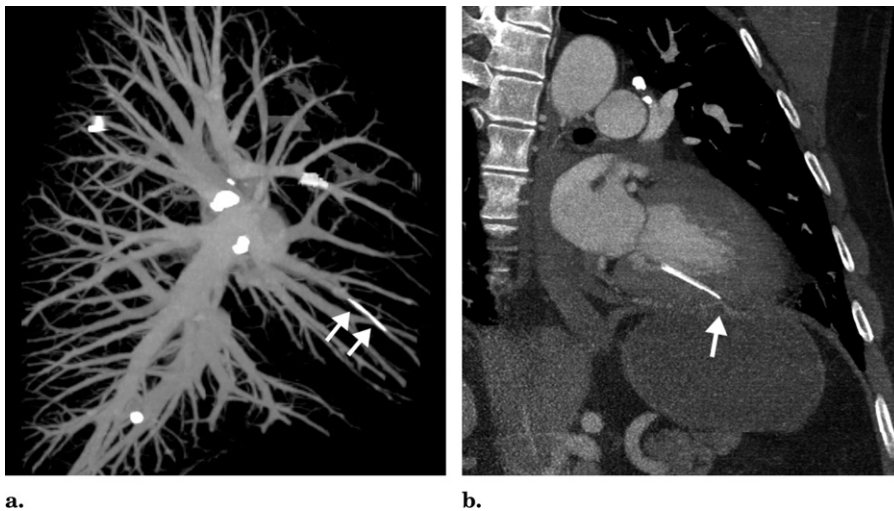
CT scan shows metallic foreign body (arrows) in the right middle pulmonary artery (a) and inferior wall of the left ventricle (b). There is complete perforation of the left ventricular wall by the foreign body, with the tip resting against the pericardium near the diaphragm. A prominent branch of the phrenic artery (arrow) is noted near the tip of the foreign body because of local inflammation of the diaphragm.
